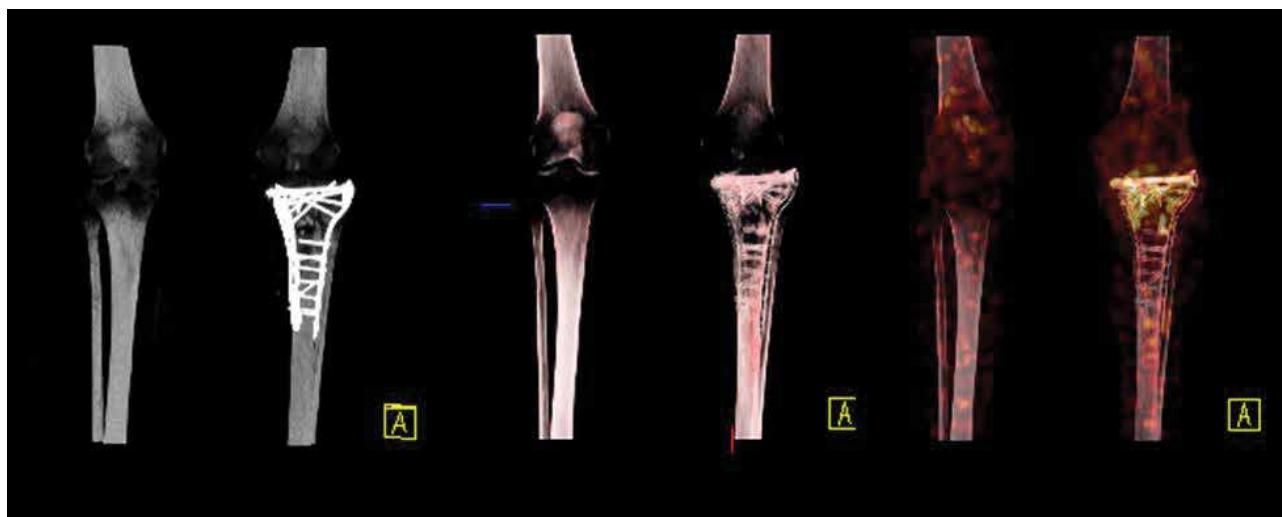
SPECT maximum intensity projection (MIP) and a volume rendering of CT show the dual plates of the internal fixation holding multiple fracture fragments in the tibia's upper end. Volume rendering of fused SPECT/CT shows intense uptake of ^{99m}Tc -labelled antigranulocyte antibodies in the region of the fracture fragments and internal fixation plates. This suggests an active infection throughout the entire proximal end of the tibia.
